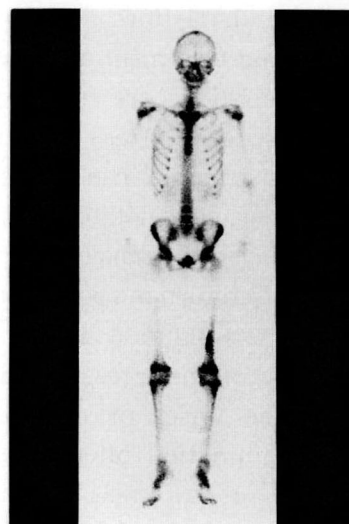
Bone scintigrams demonstrated increased uptake in the distal femur.
